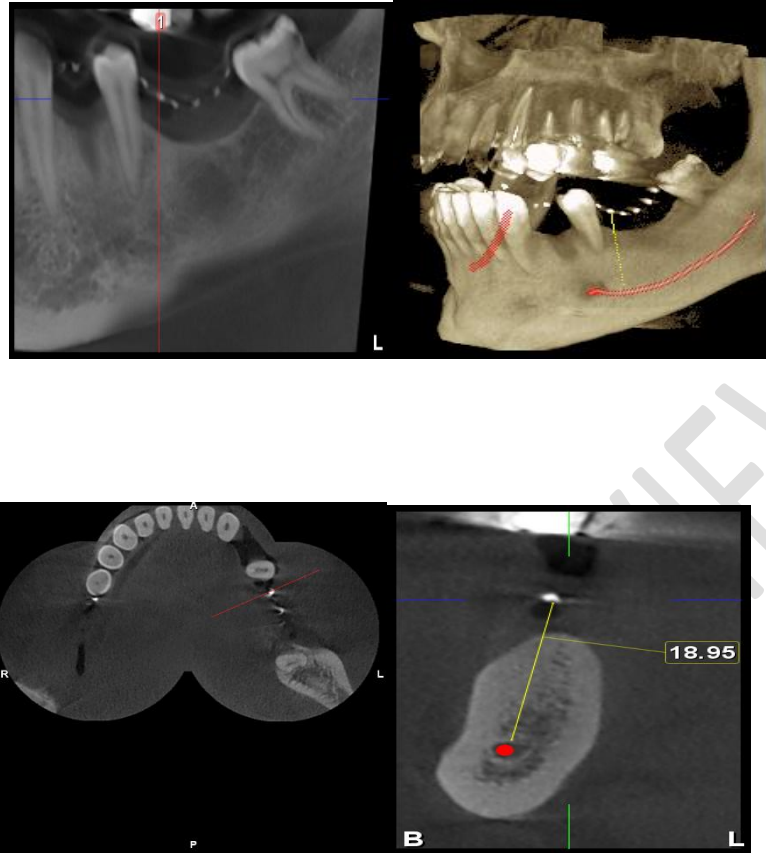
CBCT radiography and measurement of specified points
